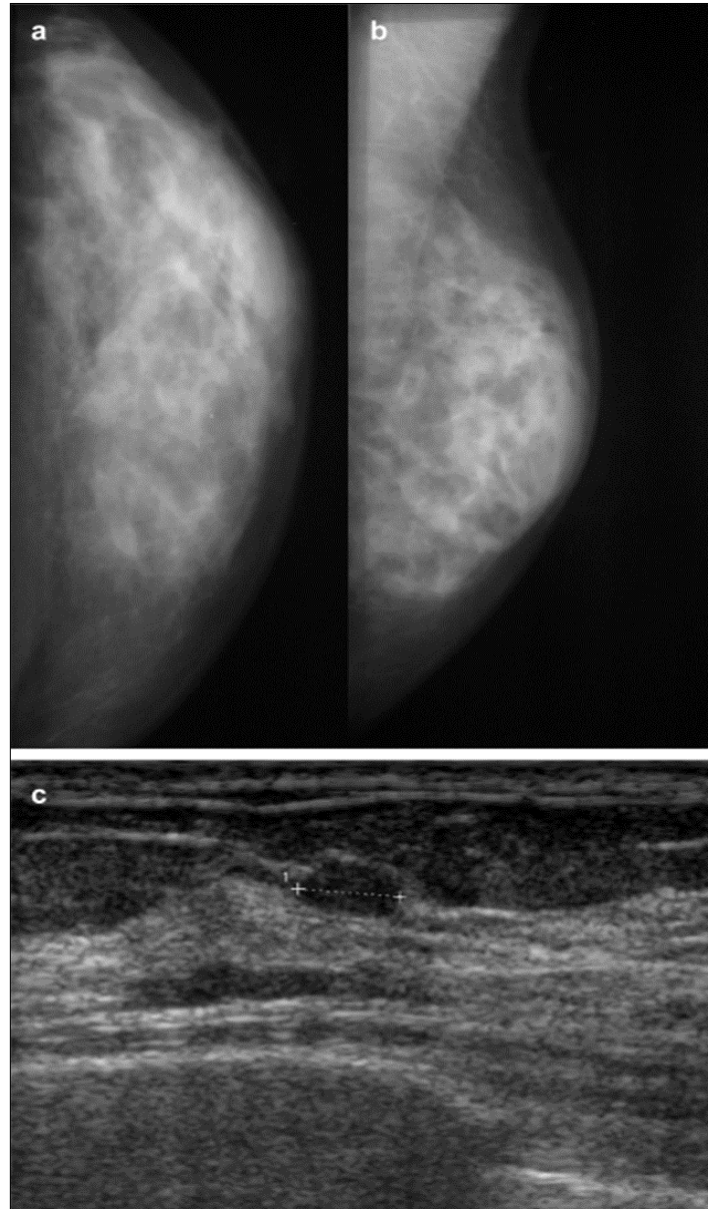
A & b: Mammograms and Figure C: Ultrasonography
